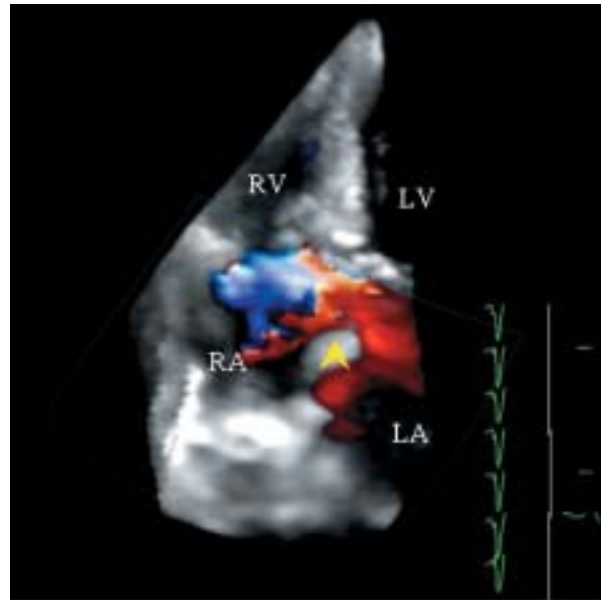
Color Doppler three-dimensional echocardiogram
